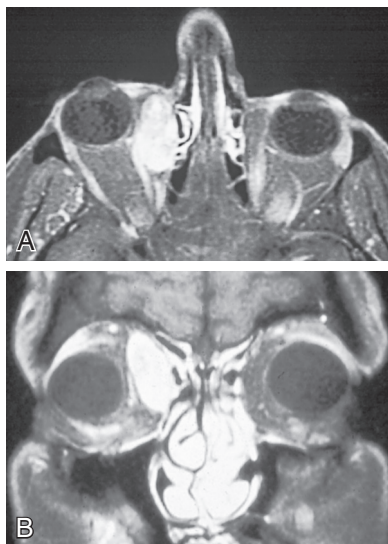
A and B, T1-weighted magnetic resonance images of the orbit with fat suppression.
